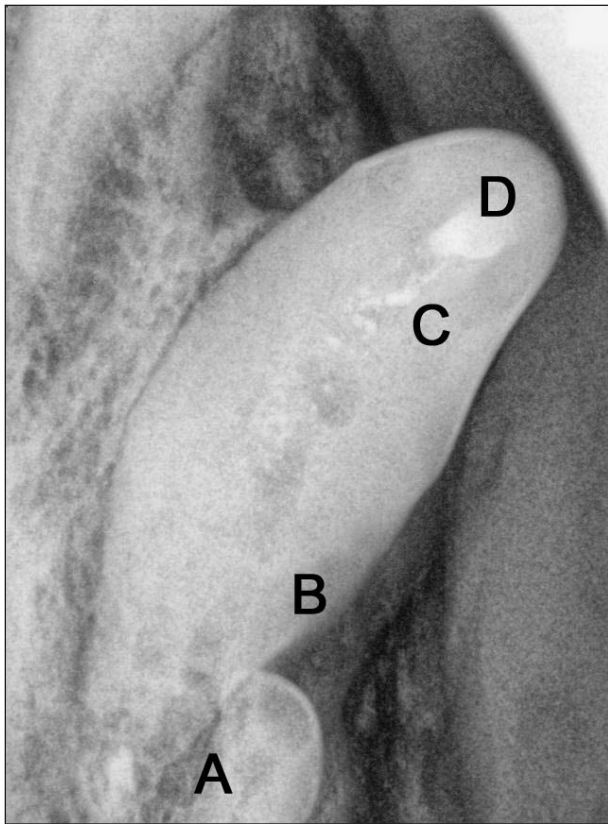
Same radiographic view as in Figure 1. Notice the area of root resorption (A), with osteolysis of periapical bone and loss of the lamina dura; radiopaque material is evident in the periapical area. In addition, there is a defect in the wall of the tooth (B), and the pulp canal contains poorly defined radiopaque densities (C). An amalgam restoration (D) is also evident.
